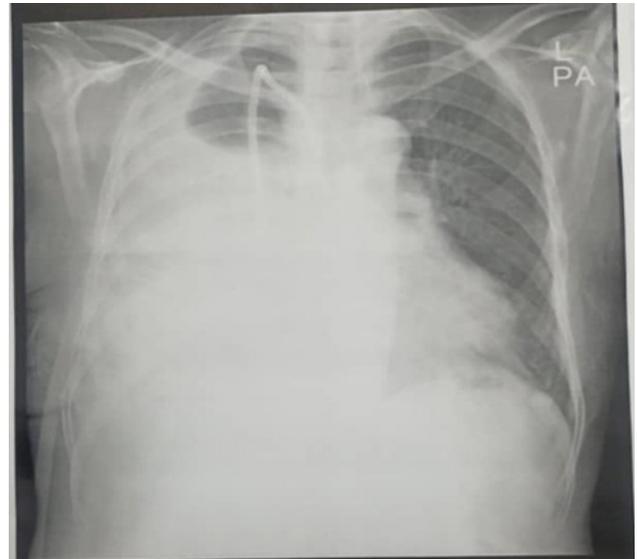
Chest X-ray revealed complete whitening of the right hemi-thorax.
